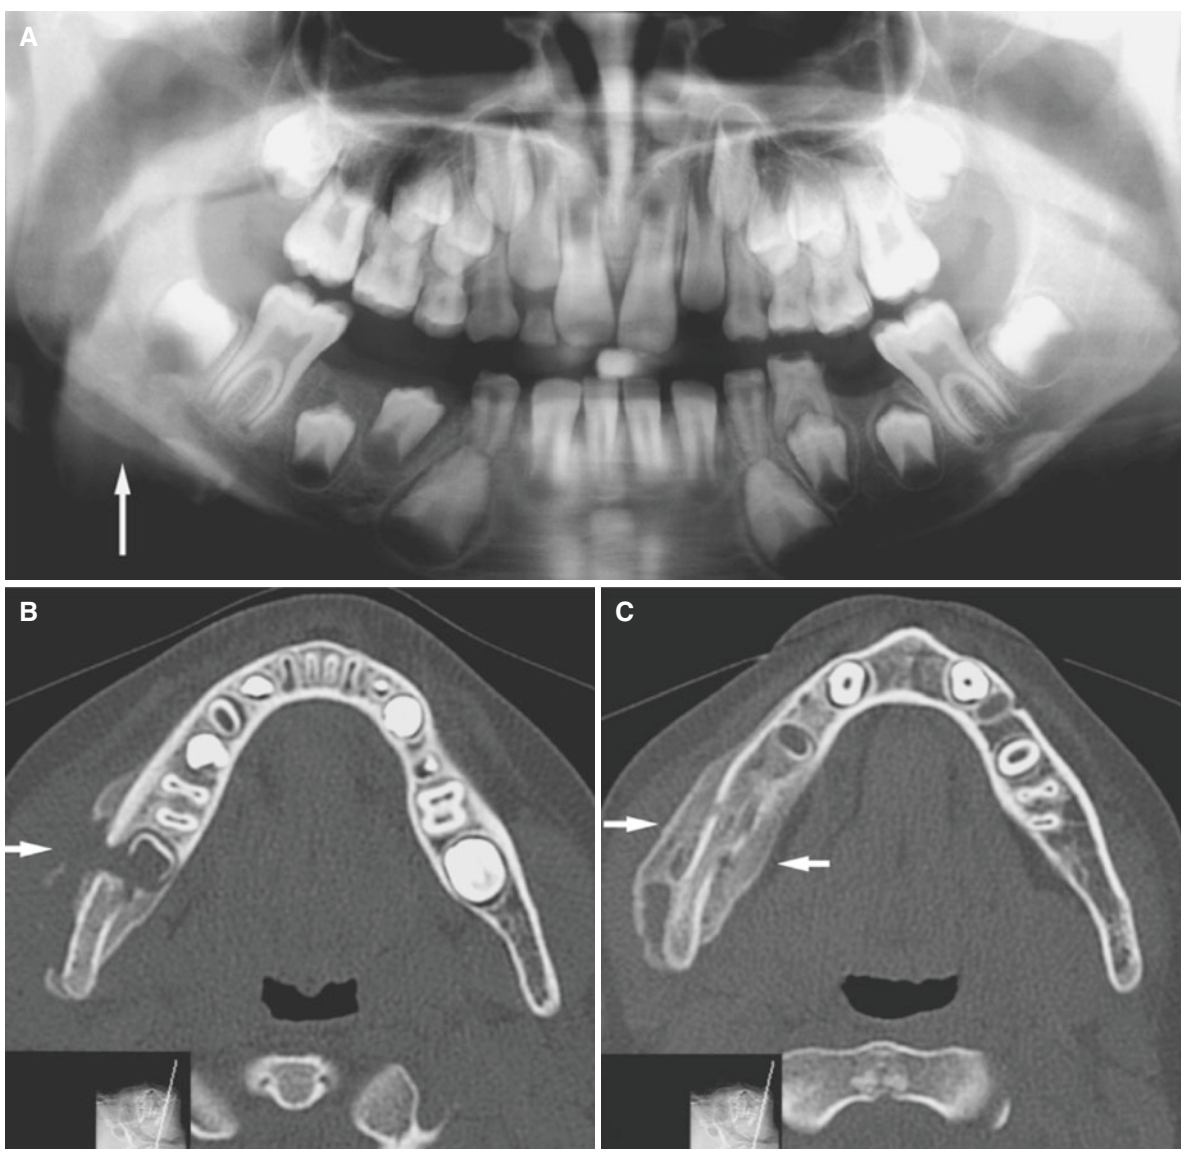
Osteomyelitis with periostitis, mandible; 8-year-old male with variable right perimandibular swelling and pain for some months. (A) Panoramic view shows periosteal reaction (*arrow*). (B) Axial CT
